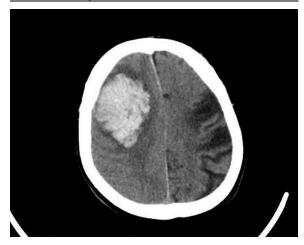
Brain CT ScaN OF PATIENT
